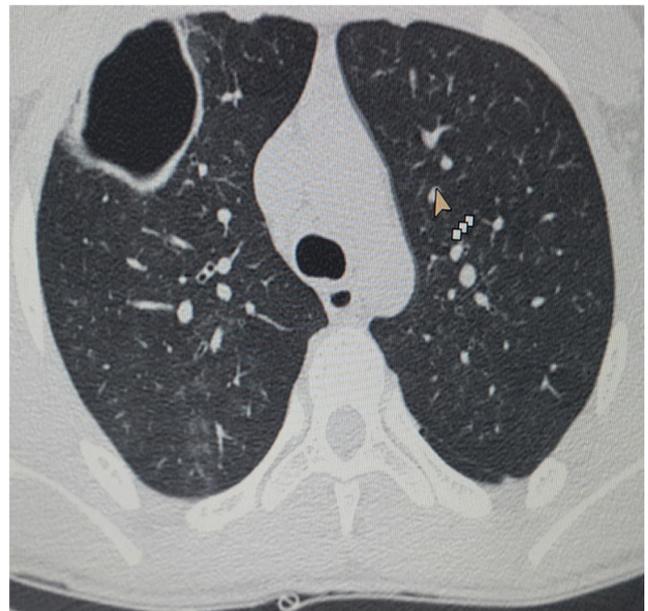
Post-aspiration CT thorax showing the empty cyst sign.
